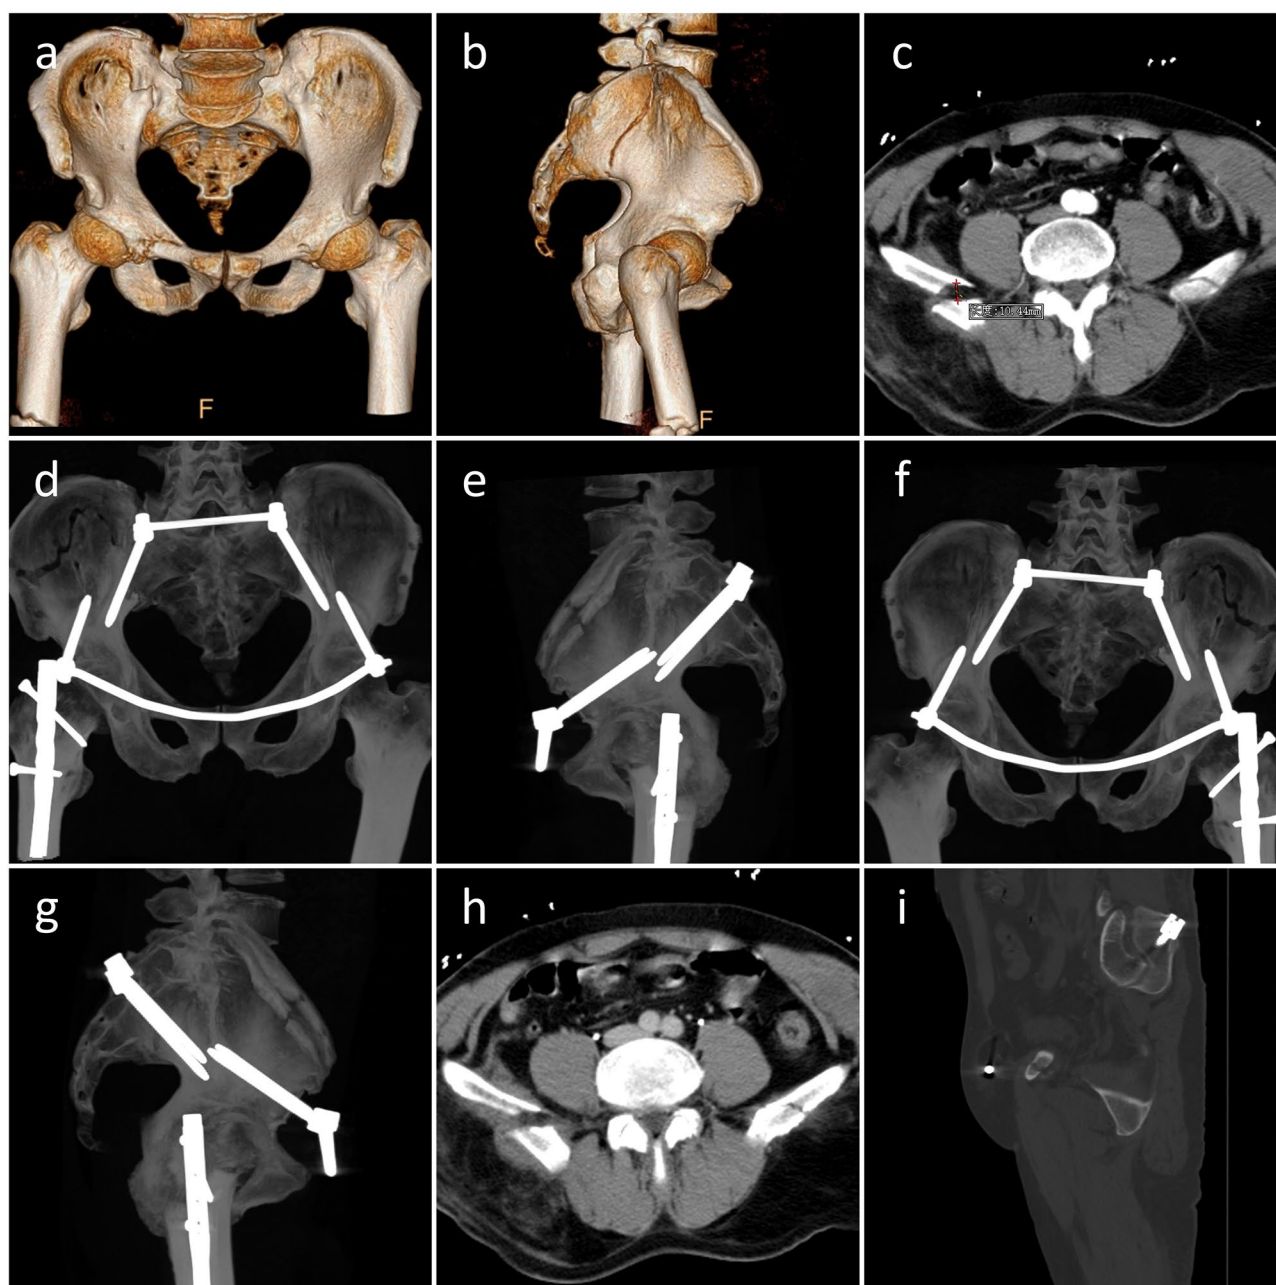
Case 2: Preoperative CT of a 55-year-old male patient with pelvic fracture due to a fall revealed multiple pelvic fractures and a significantly displaced iliac fracture (a–c). CT performed at 2 weeks postoperatively showed adequately reduced anterior and posterior rings with firm and well-positioned internal fixation (d–h). Removal of sufficient bone to ensure complete burial of the screw cap (i)
